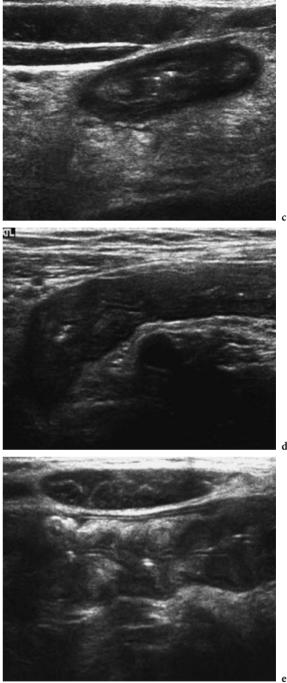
a Enteroclysis in a boy with Crohn disease. The terminal ileum is affected and narrowed with prestenotic dilatation. There is an effacement of the mucosal pattern and septation of loops. Infiltration of the mesenteric fat causes isolation of the terminal ileum. b Crohn disease. CT demonstrates thickened small bowel up to distended cecum. c-e Child with Crohn disease. The US images show an irregular bowel wall thickening and a hyperechoic thickened mesentery
